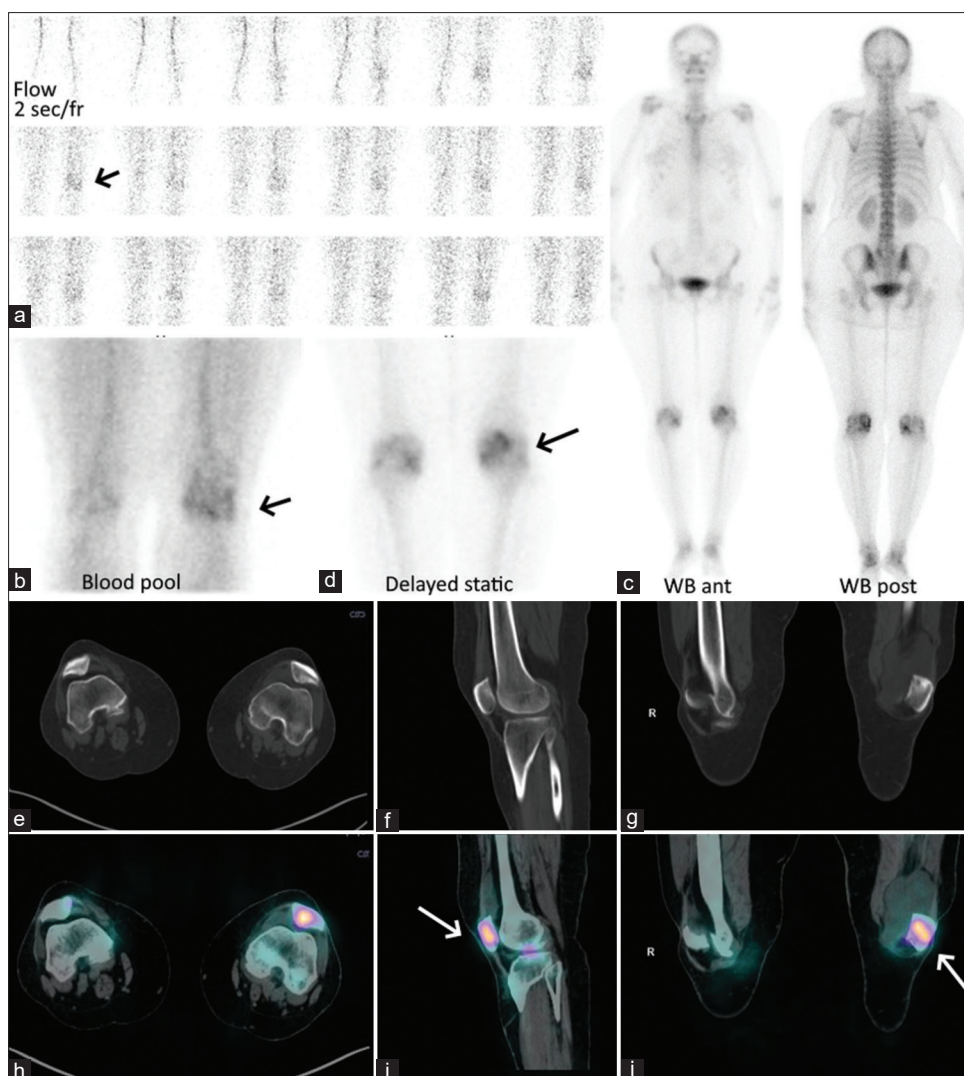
Three phase skeletal scintigraphy shows increased flow, (a) blood pool (b) involving the left suprapatellar region along with increased tracer uptake in the left knee in delayed images (c,d). SPECT-CT images (e-j) localize increased tracer uptake to left patella along with fluid collection in the left suprapatellar bursa.
